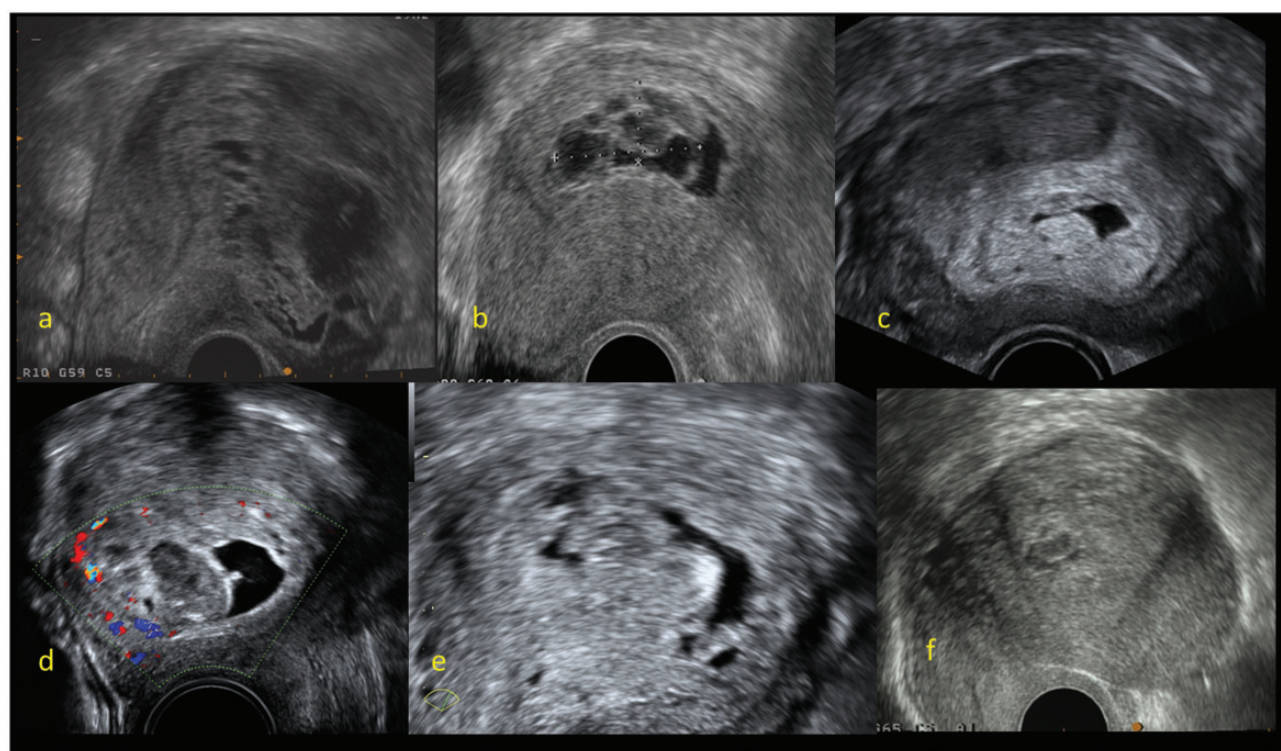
Missed complete moles (false negative ultrasound scans).
